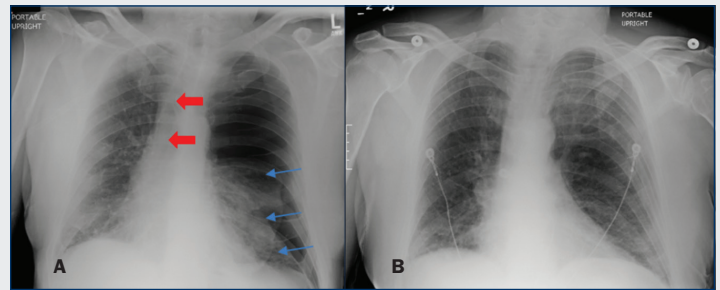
Chest x-ray of tension pneumothorax (A) as evidence of significant mediastinal shift (red arrows) and left lung collapse (blue arrows). (B) Lung re-expansion post chest tube placement.
